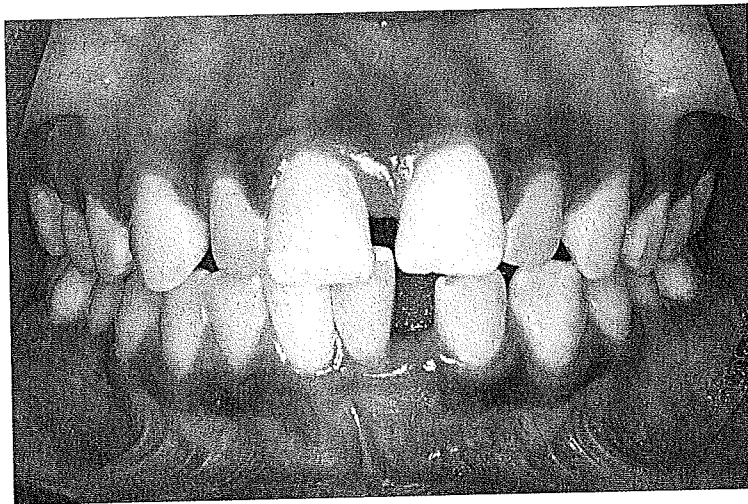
Localized aggressive periodontitis (LAP) with minimal inflammation (upper panel), but bone loss around incisors and first permanent molars is evident on X-ray (lower panels).
